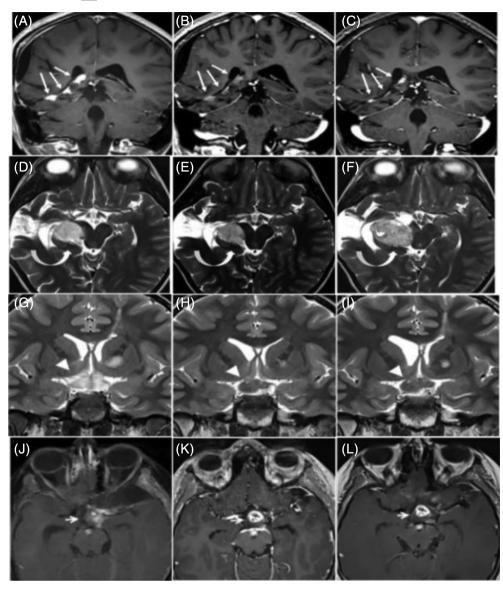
MRI. A, Pt #2 (a,b, c): Coronal T1w images show the progressive reduction, PR (more than 50%) of the residual tumor areas (arrows) from the baseline (a) and during treatment at 18 mo (BR, b) and at 4 years (c). B, Pt #3 (d,e,f): Axial T2w images demonstrate the progressive tumor growth, PD, (curved arrows) during the treatment, from the baseline (d), at 12 mo (BR, e) and at 3 years (f). C, Pt #5 (g,h,i): Coronal T2w images show the tumor volume (arrow head) at baseline (g), and during treatment at 48 months (BR, h) and at 5 years (i), demonstrating stable disease, SD. D) Pt #10 (I,m,n): Axial Gd T1 images demonstrate the presence of the residual lesion (arrows) after surgery (I), at the baseline (m) before the treatment and at 1 year after treatment (SD, n)
